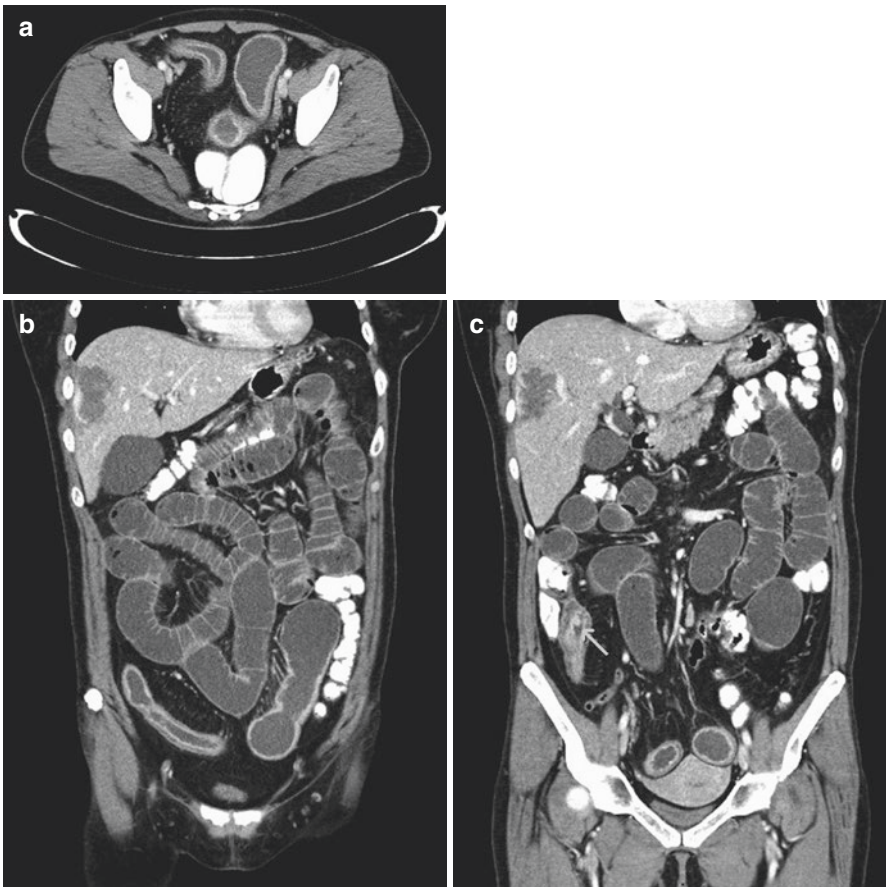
A 53-year-old female patient with severe, extensive, active Crohn's disease in the ileum on CT enterography with the following mural and extramural features: circumferential wall thickening, increased mural enhancement, mucosal hyperenhancement, mural stratification, enhancing pseudopolyp (arrow on the coronal image, c), "comb sign," and fibrofatty proliferation
